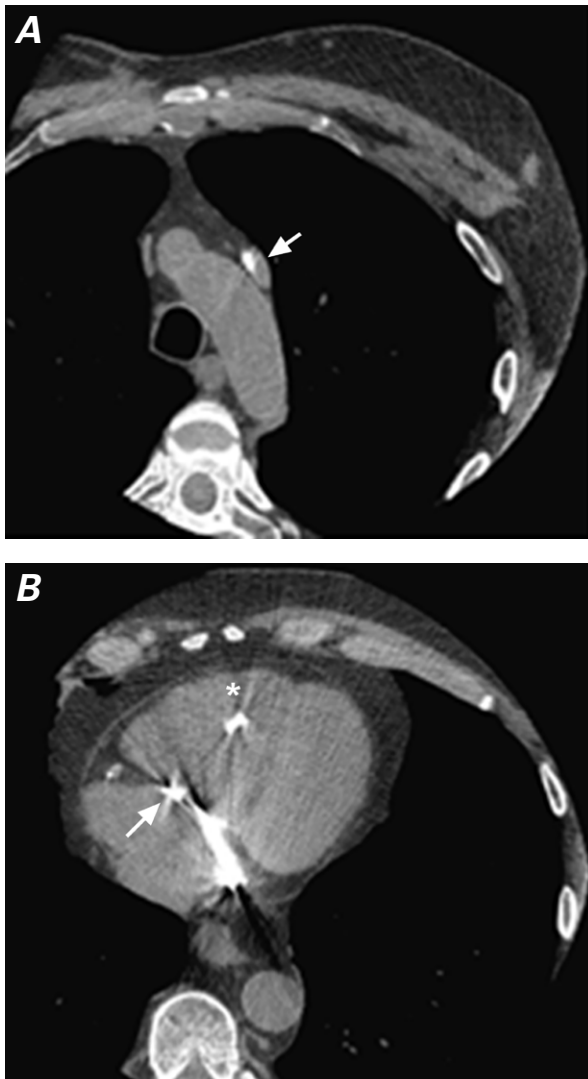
Chest computed tomograms with contrast show the pacemaker leads entering the venous system through the left subclavian vein and passing into A) the left persistent superior vena cava (arrow), B) the dilated coronary sinus (arrow), and the right ventricle (asterisk).
